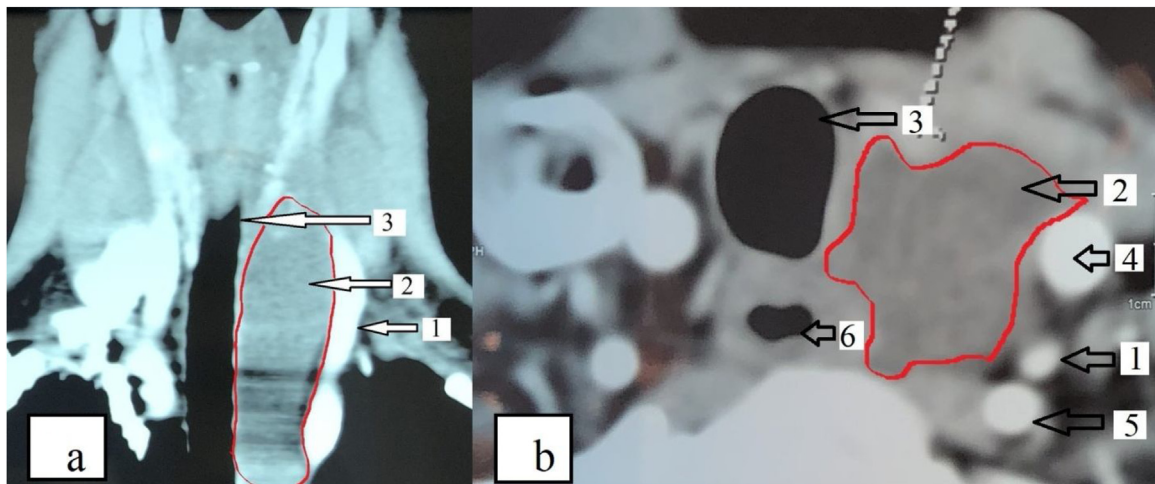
Multi-slice CT scan with angiography: 2a - Sagittal scan, 2b - Axial scan. 1 - left common carotid artery; 2 - cyst of the left lower parathyroid gland; 3 - trachea; 4 - left internal jugular vein; 5 - left subclavian artery; 6 - esophagus.
